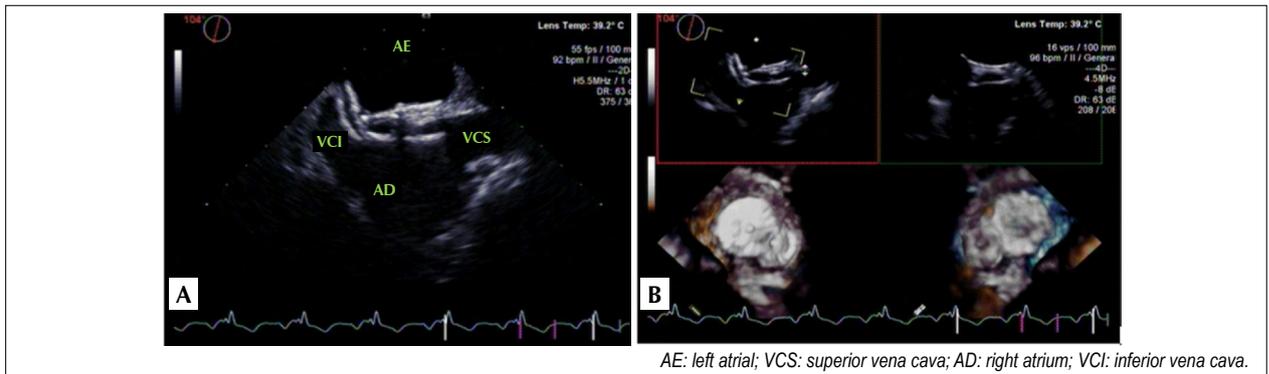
Echocardiogram performed on September 1, 2021, in the late postoperative period of percutaneous closure of the multi-fenestrated atrial septal defect. A. Two-dimensional image of the occluding device in the topography of the interatrial septum. B. Three-dimensional image of the prosthesis.
